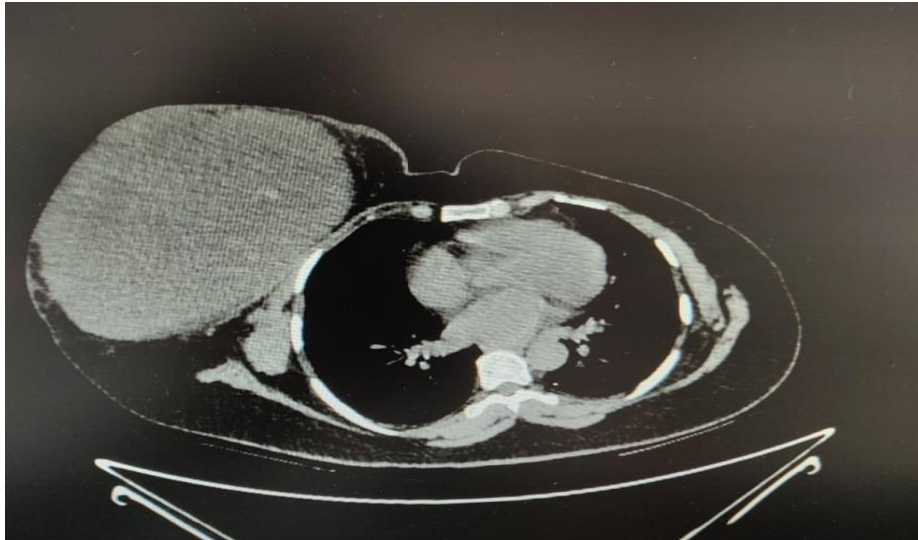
CT imaging demonstrating the well circumscribed lesion
